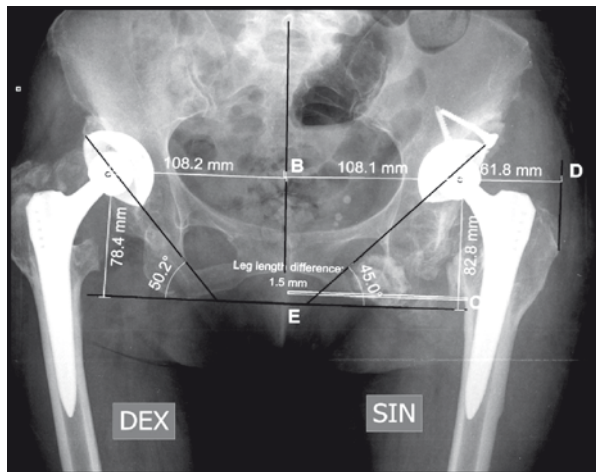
A–P radiograph of the pelvis– THR of both hip joints with uncemented EP(W.Link uncemented T.O.P. acetabular components located into the secondary sockets, bone grafting of the roof of the left acetabulum is made for better coverage of the cup ,uncemented SLPluss stems and metal ball heads used;point A–the rotation center of the left hip joint;AB–the horizontal location of RC;AC–the vertical location of RC;AD–the offset;angle AEC–the inclination angle of acetabular component into the pelvis)
